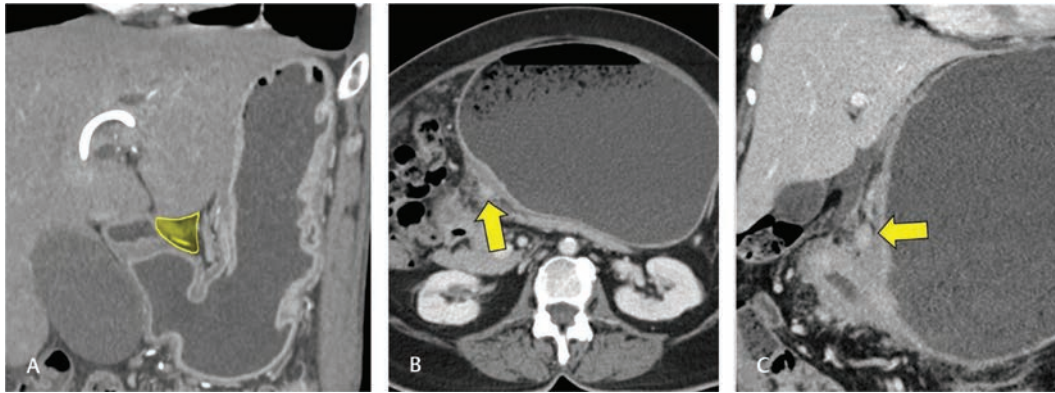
Station 5. Coronal reformatted CT in arterial phase (A) depicts the suprapyloric region (yellow area in A) with proximal part of right gastric artery along which lie the station 5. Axial and coronal reformatted CT (B) and (C) in venous phase shows suprapyloric nodes (arrow) and pyloric wall thickening. CT, computed tomography.
